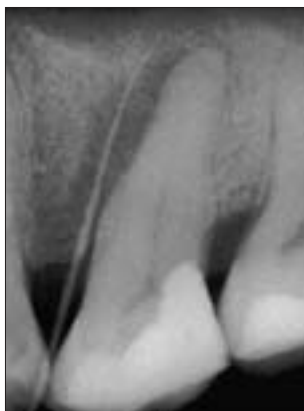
Follow-up radiograph at one year; the radiolucency has completely resolved and the tooth is asymptomatic, indicating it has healed.
